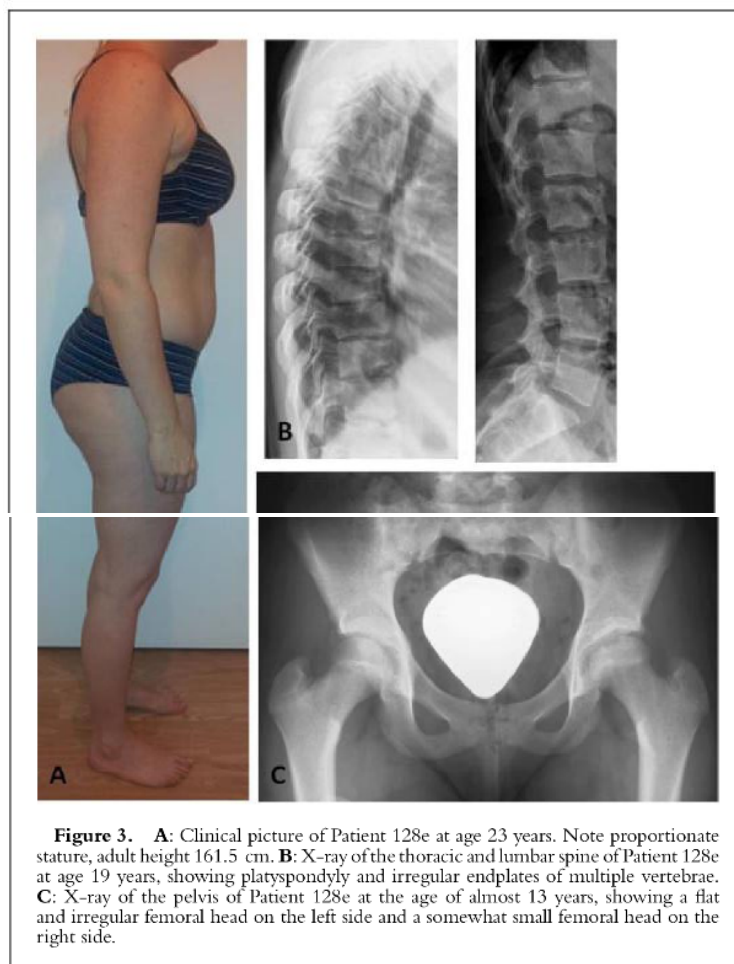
A: Clinical picture of Patient 128e at age 23 years. Note proportionate stature, adult height 161.5 cm. B: X-ray of the thoracic and lumbar spine of Patient 128e at age 19 years, showing platyspondyly and irregular endplates of multiple vertebrae. C: X-ray of the pelvis of Patient 128e at the age of almost 13 years, showing a flat and irregular femoral head on the left side and a somewhat small femoral head on the right side.
